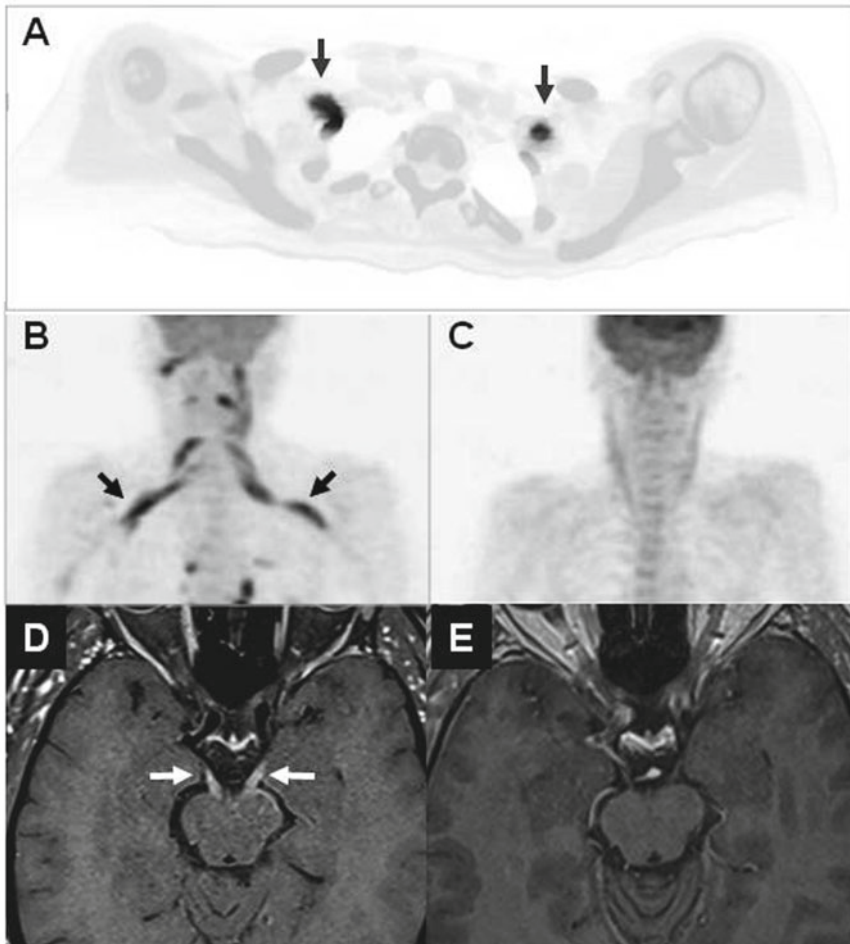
Imaging demonstration of response to treatment in neurolymphomatosis. (a and b) FDG-PET scan (a is an axial view with CT co registration) of a patient with a history of non-Hodgkin lymphoma who presented with asymmetric upper extremity weakness and muscle wasting associated with mild proximal pain. The PET demonstrated abnormal uptake of the tracer in cervical spinal nerve roots (b) and along both brachial plexi (a and b) suggesting infiltration of the neural structures by the lymphoma. (c) FDG-PET scan of the same patient as in a and b after treatment with high-dose methotrexate
